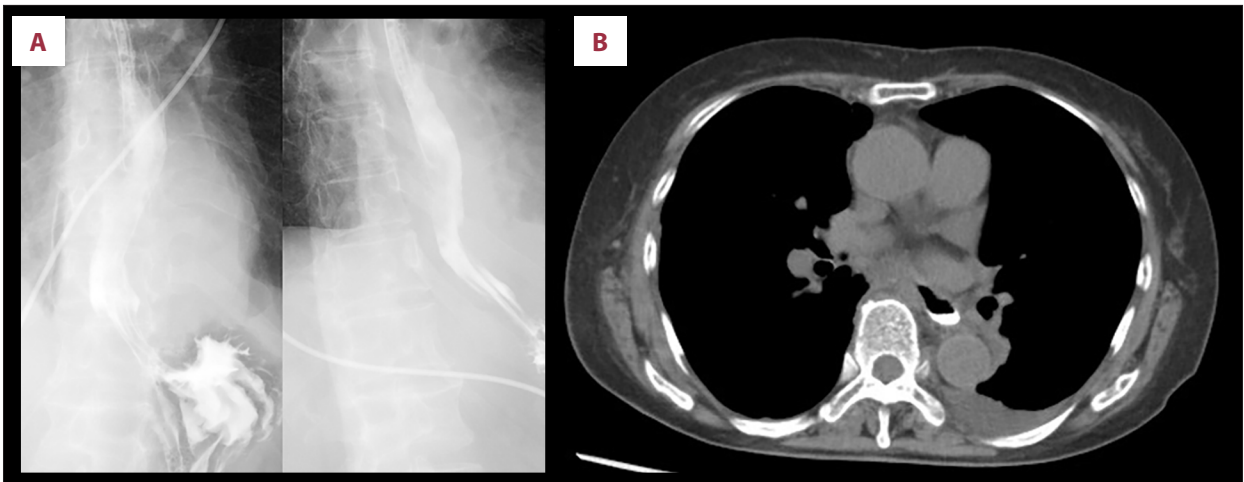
Postoperative imaging findings. (A) Contrast esophagography using Gastrografin demonstrating no evidence of leakage. (B) Computed tomography performed immediately after esophagography confirming the absence of leakage.
